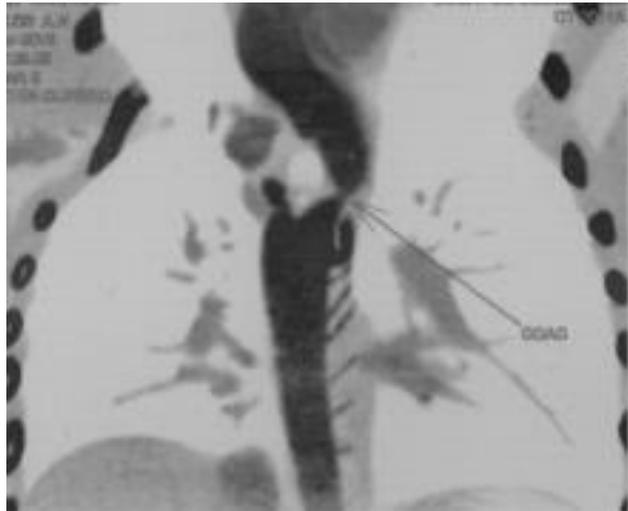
CT image depicts the coarctation of the rightsided aortic arch. Diameter of the aorta at coarctation (COAC) site is 4 mm. Kommerell's diverticulum (arrow) can be seen at the origination of the right subclavian artery.
